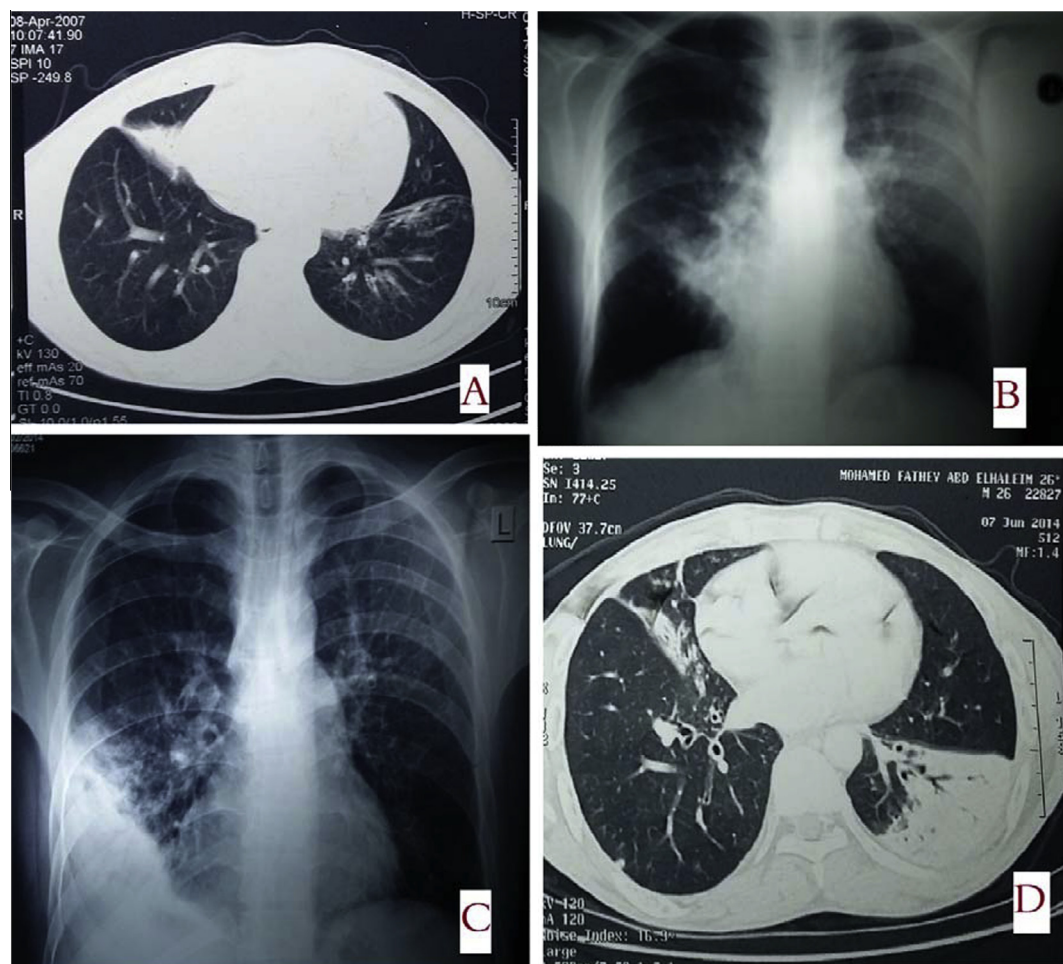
(A) Chest Ct shows middle lobe consolidation, and minimal bronchiectasis at left lower lobe. (B) Chest X-ray: middle lobe consolidation. (C) Right lower lobe consolidation with effusion. (D) Left lower lobe consolidation, with middle lobe bronchiectasis.
